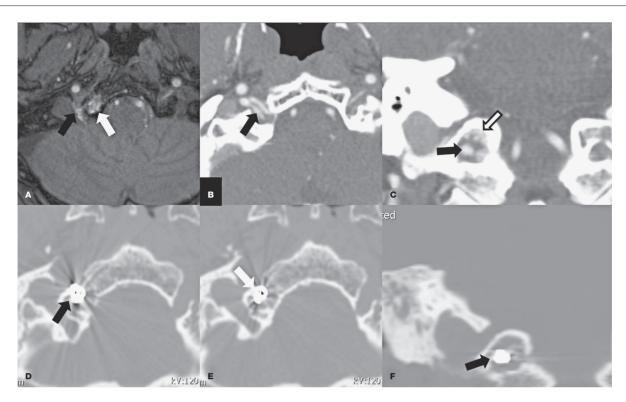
Case 7. Pre-embolization time of flight MR angiography source image at the level of hypoglossal canal shows high flow inside the right adjacent basiocciput (A, white arrow). The fistula (black arrow) is well depicted on CT angiography source (B) and coronal reconstruction images (C), on which the bone component is also shown (white arrow). Post-embolization CT angiography shows a coil mass inside the hypoglossal canal (D, F) and basiocciput (E, white arrow).
